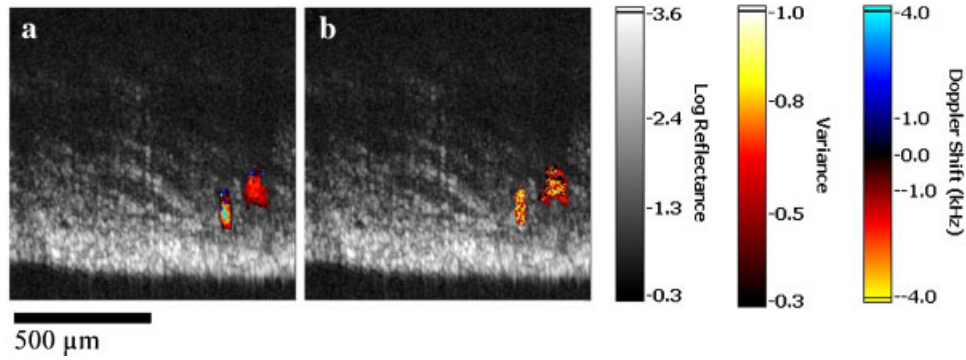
IS-DOCT image showing (a) color Doppler and (b) velocity variance maps of detected blood vessels in tumor before PDT treatment. [Figure can be viewed in color online via www.interscience.wiley.com.]
